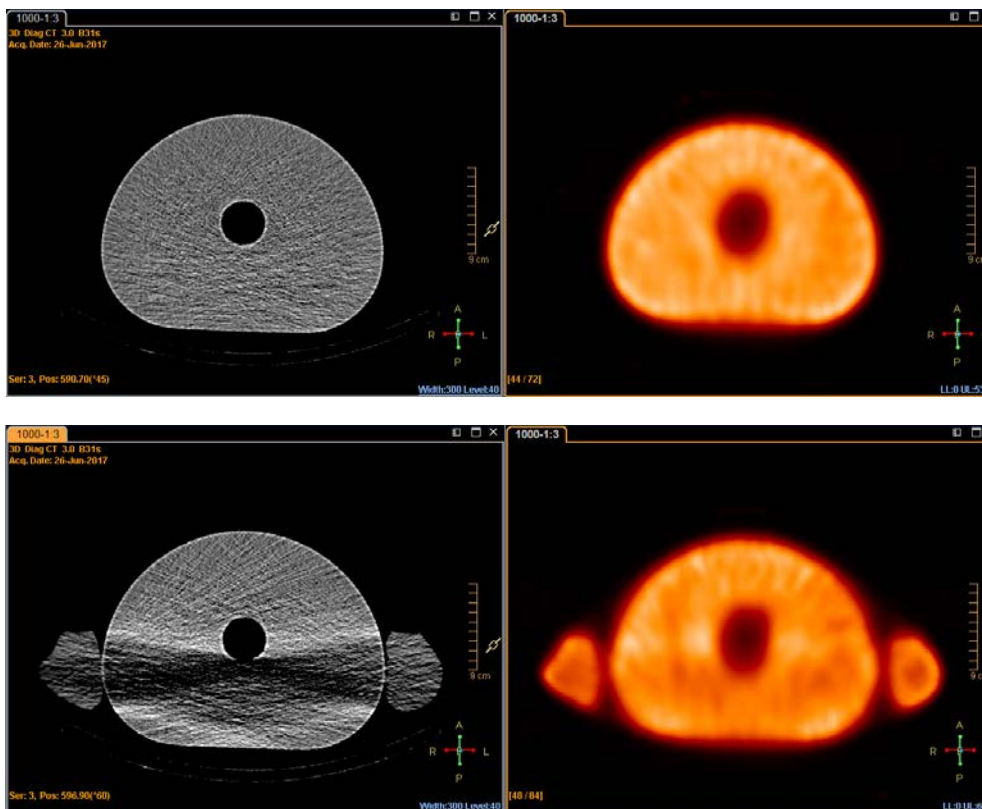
CT scan of 80 kV and 10 mAs, significant beam hardening artefacts are observed in the CT image when the arms are down along the body. The influence in the SPECT image is visible.
